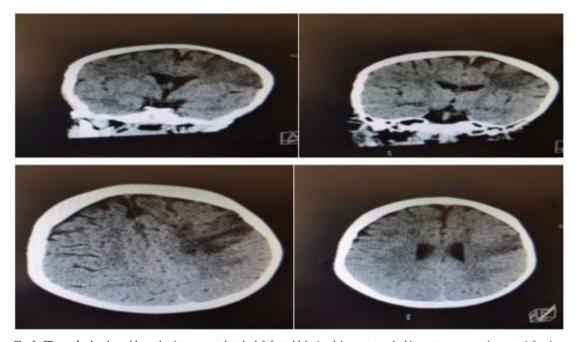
CT scan brain: showed hypo-density area noted at the left frontal lobe involving cortex and white matter, representing acute infarction.
